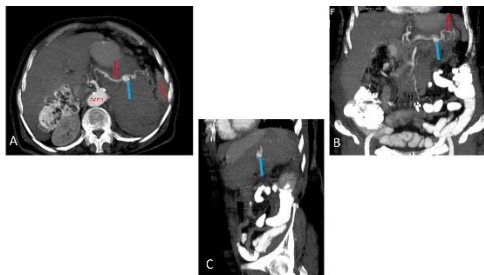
Axial, Sagittal and Coronal without contrast computed tomography (CT) image exposed a splenic artery aneurysm (SAA).
